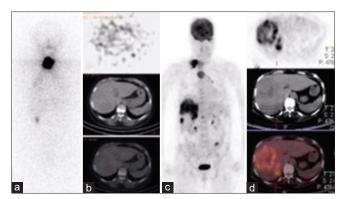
Diagnostic imaging. (a) Planar postradioiodine I-131 whole-body imaging in anterior view showed foci of radioiodine uptake in the lower neck and in the upper thorax. (b) Abdomen axial single-photon emission computed tomography/low tomography/fusion single-photon emission computed tomography/liver window images performed to identify the exact anatomical locations and there was no any abnormal radioiodine uptake in liver suggestive of malignancy. (c) The maximum intensity projection (maximum intensity projection image) by positron-emission tomography revealed an increased fluorodeoxyglucose uptake in liver lesions. Heterogeneous fluorodeoxyglucose uptake in neck region, lung, sternum, lumbar vertebrae, and pelvis was also seen. (d) Figures demonstrated a liver mass measured approximately 97 mm ×83 mm in the axial sections and numerous foci of intense fluorodeoxyglucose activity in both lobes of liver (SUVmax: 9.6)
